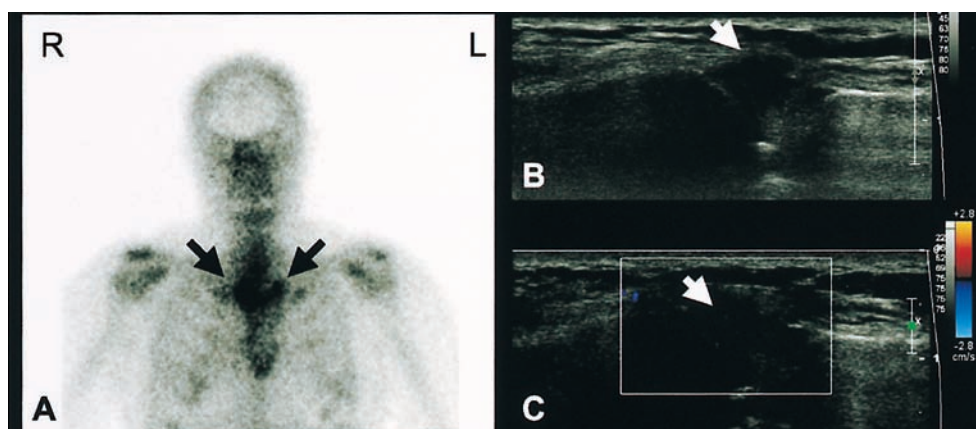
45-year-old female patient: clinical assessment showed a polyarticular form with 5 joints involved, while total-body bone scintigraphy demonstrated involvement of other articular sites. In particular, on bone scintigraphy (A) there was increased tracer uptake at sternoclavicular joints (arrows) in the absence of symptoms or signs of clinical involvement. B-mode ultrasonography (B) of the right sternoclavicular joint demonstrated gray-scale changes of synovial hypertrophy (arrow); on the echo-color Doppler scan (C) note the absence of hyperemia (arrow).
